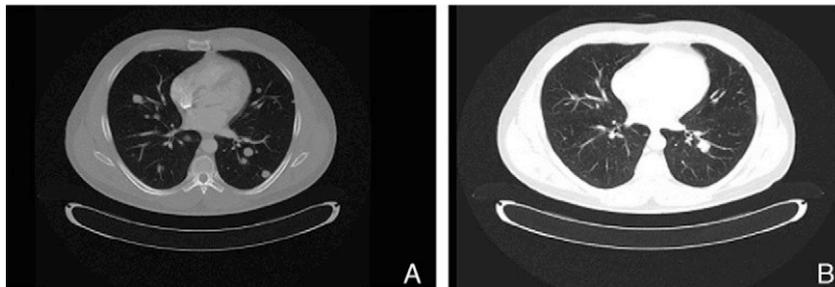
Disappearance of most of the lung metastases following 3 months of imatinib therapy in patient no. 1. A, Computed tomography (CT) scan performed on November 23, 2009, prior to treatment. B, CT scan performed on March 2, 2010, after 3 months of treatment with imatinib.
